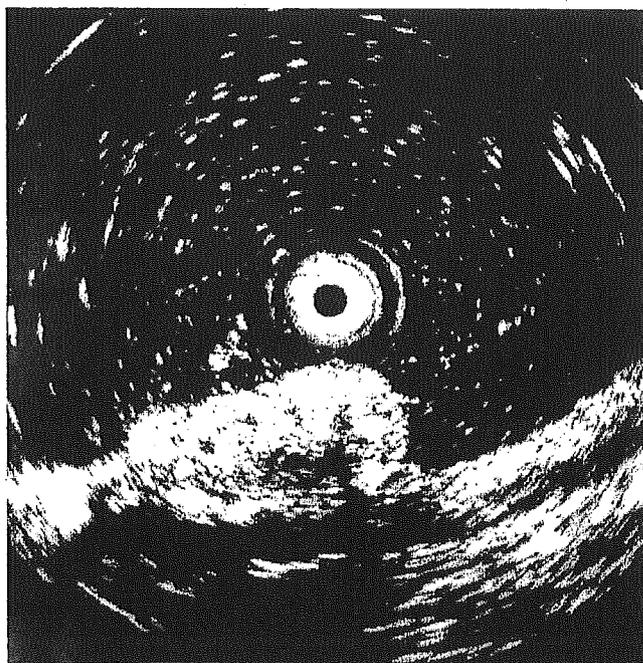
Endoscopic ultrasonography (EUS) revealed that a hypoechoic mass covered with hyperechoic lesion that had anechoic areas interrupted the second and third layers of the gastric wall.
